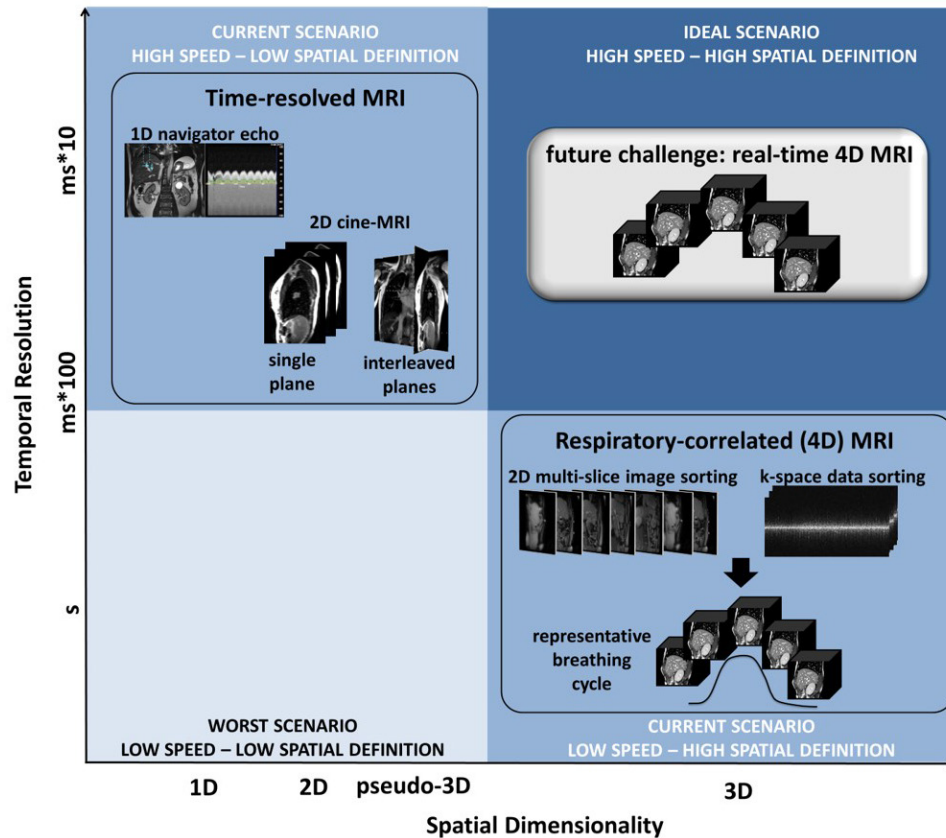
Image acquisition approaches in terms of temporal resolution versus spatial dimensionality. The ideal acquisition strategy would yield real-time 4D MRI; at present this is not possible and remains a future challenge.
